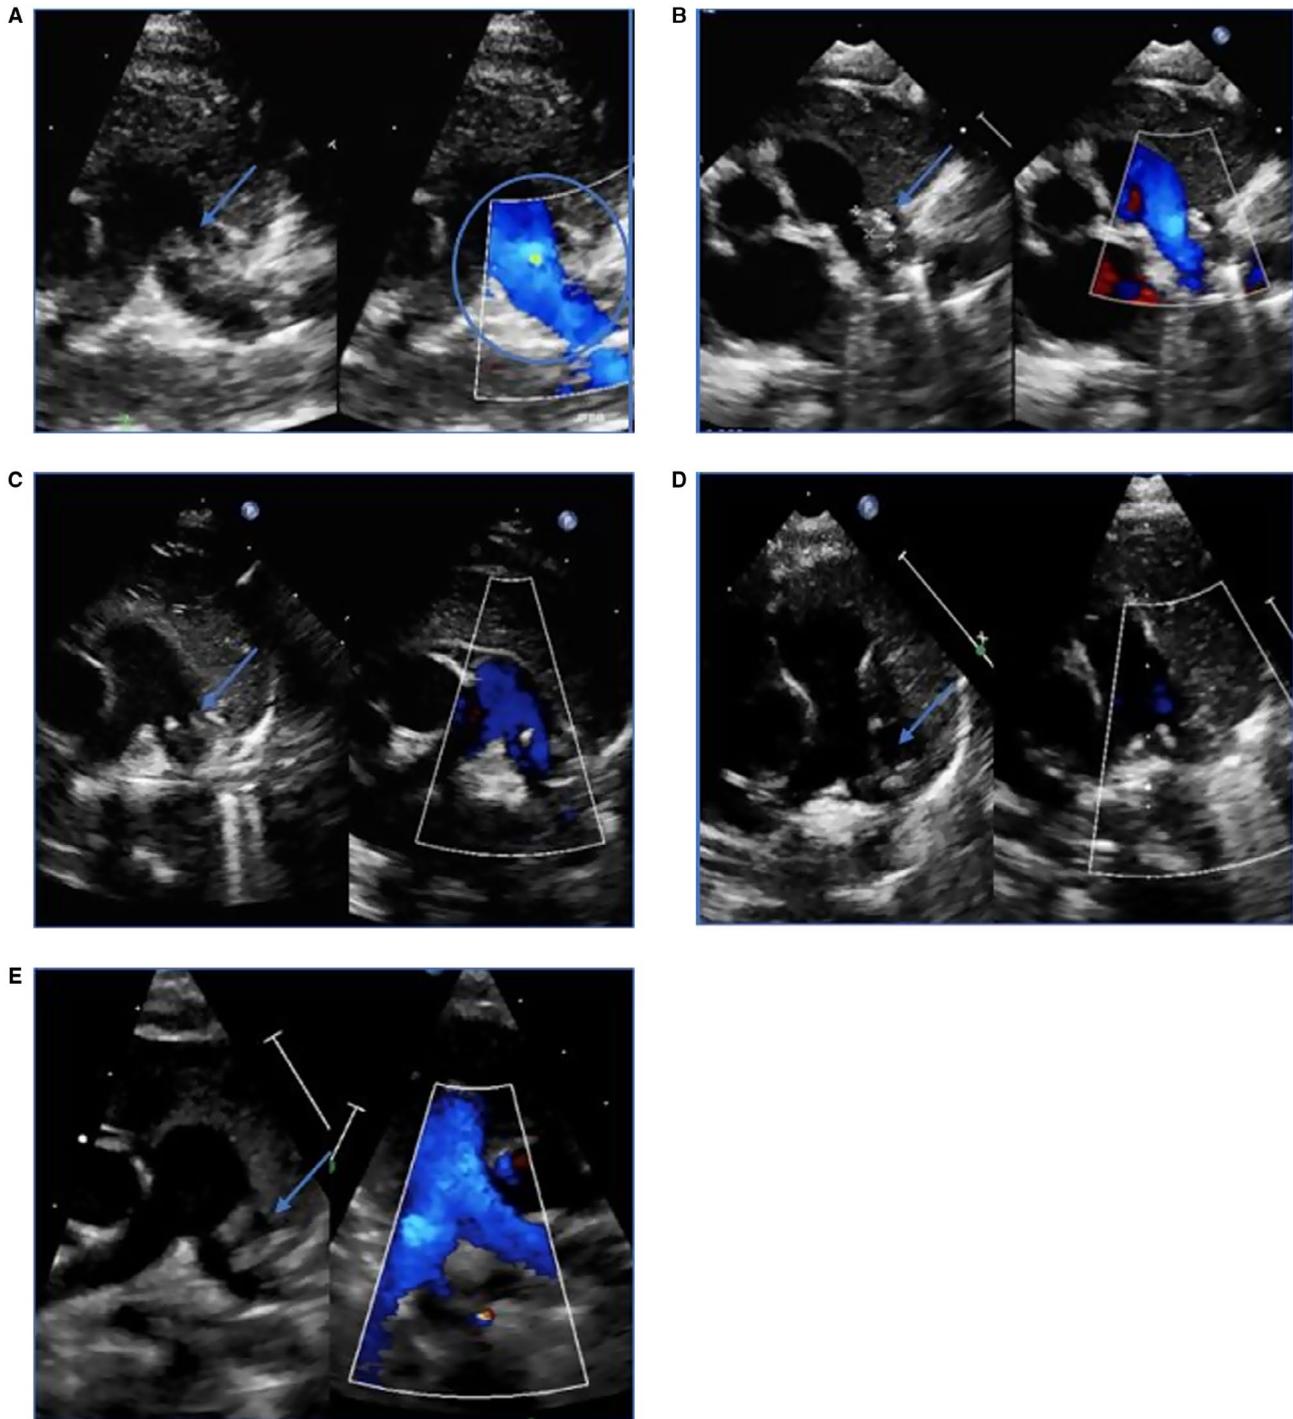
Two-dimensional transthoracic echocardiographic long-axis view of the pulmonary arteries and nonpatent ductus arteriosus demonstrating vegetation's evolution (arrow) in dimension and echogenicity at admission (A) 8 × 3 mm; week 1 (B) 8 × 3 mm; week 2 (C) 5 × 4 mm; week 4 (D) 5 × 3 mm; week 9 (E) 5 × 3 mm. Figure A shows the turbulent blood flow (circle) in the left pulmonary artery accelerated by a systolic pulse wave Doppler gradient of V_{\max} 180 cm/s compared to the right pulmonary artery V_{\max} 141 cm/s, figure B-E demonstrated a normalized systolic pulse
